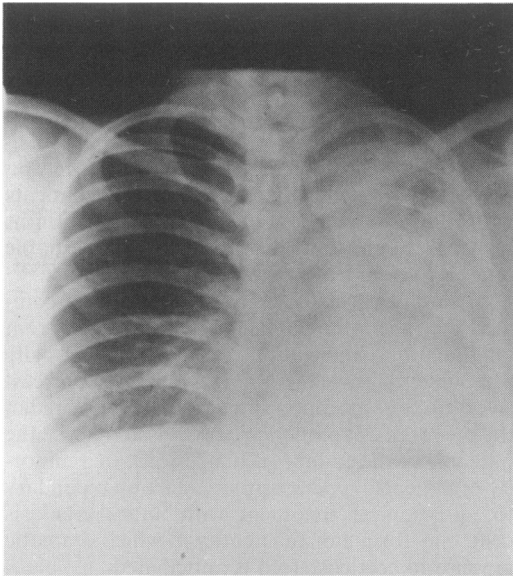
Chest radiograph of patient 7 shows failure of resolution of consolidation of left lung despite adequate antituberculosis treatment.
